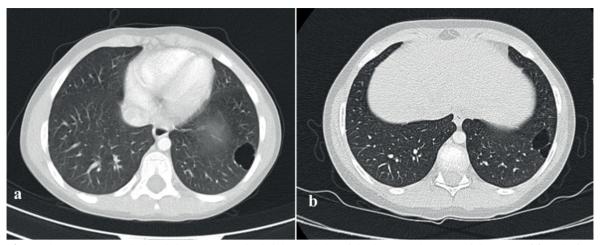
Thorax CT revealed stabile air cyst in the left lower lobe of the lung, at the time of diagnosis (a) and after 2 years (b).
